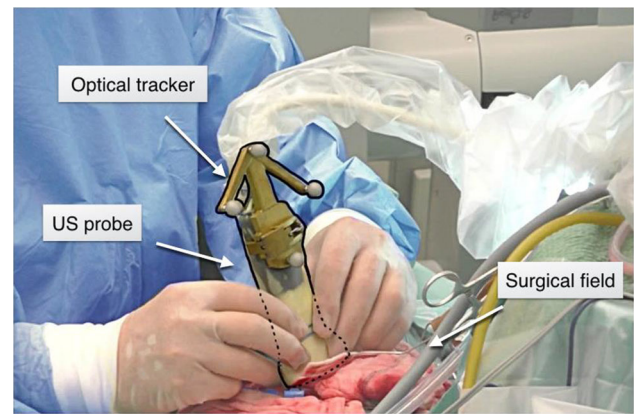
Intra-operative ultrasound image acquisitions during surgery. Ultrasound images were obtained using an optically tracked ultrasound transducer
